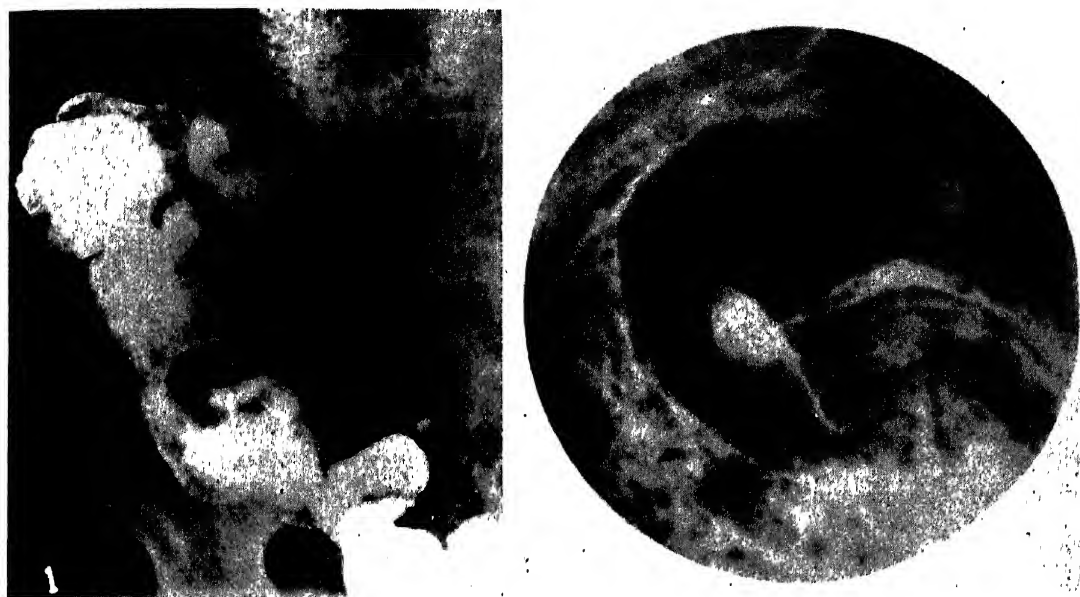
Enlargement of the ileocecal valve. Hypertrophy and edema of the ileocecal valve. A, roentgenogram taken without pressure, after ingestion of barium, shows a large defect about the ileocecal junction, interpreted originally as suggesting slight intussusception. B, roentgenogram taken with pressure shows the defect about the ileocecal valve with the terminal ileum passing through its center. This is reproduced somewhat larger than A. Operation showed these changes to be due to edema. (R. Golden: *Am. J. Roentgenol.*)
